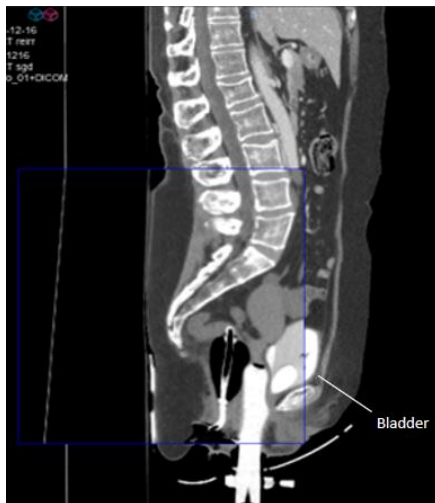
Sagittal CT image showing the delineation of the bladder.
